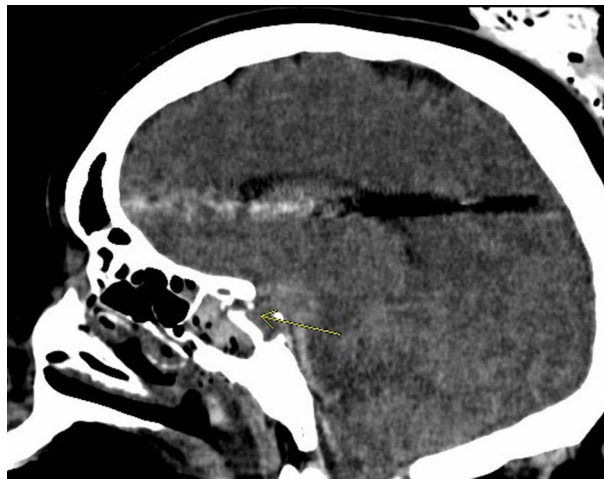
Sagittal view of the head CT. (Yellow arrow: right sided lateral sphenoid wall fracture due to force of penetrating trauma).
